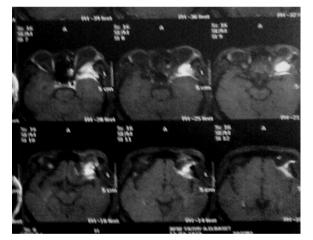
Preoperative MRI of the patient showing It sided (meningioma plaque)
